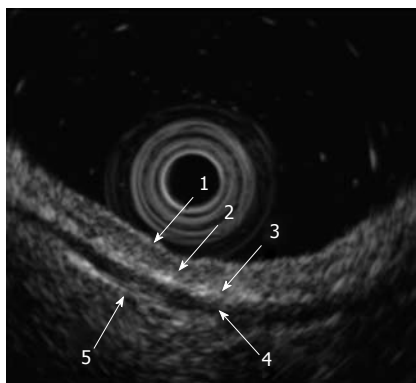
Endoscopic ultrasound features of normal gastric wall. Each numbered circle, 1-5, with a white arrow, indicates the corresponding numbered tissue layer, first through fifth.
